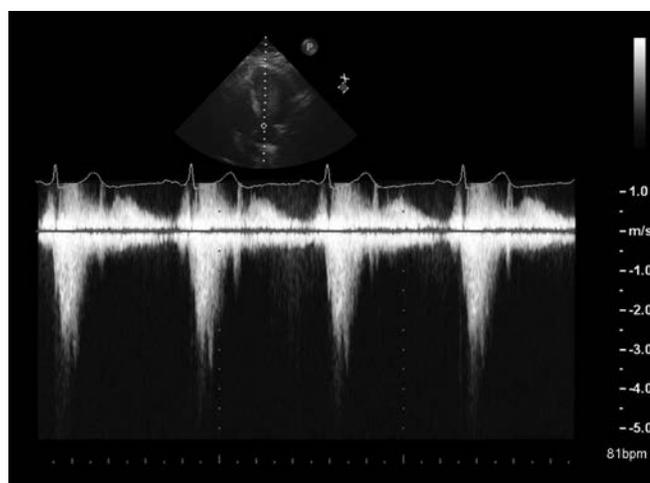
LVOT interrogation using CW Doppler demonstrating a peak gradient of more than 64 mm Hg.
